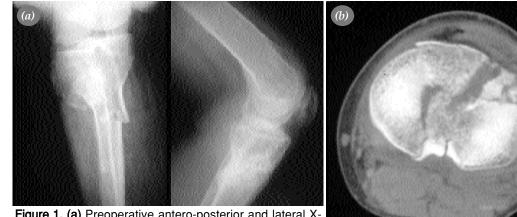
(a) Preoperative antero-posterior and lateral Xrays showing tibial plateau fracture (Schatzker type 5). (b) Preoperative CT scan of this fracture.
